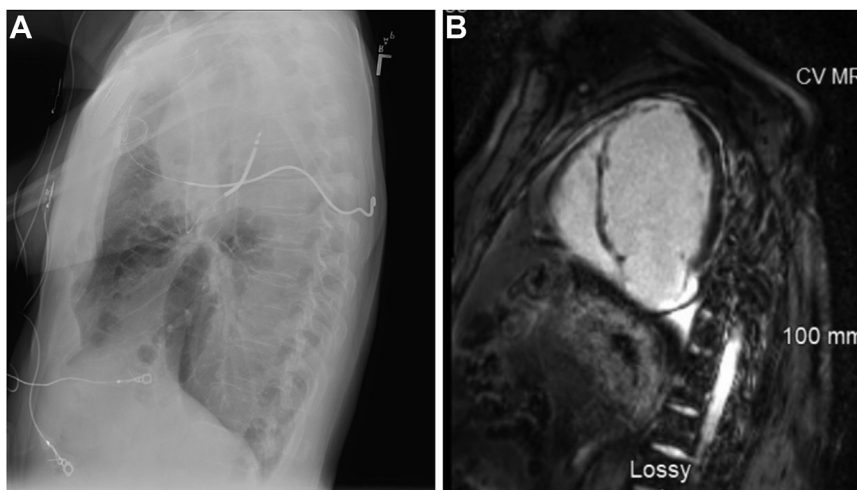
A: Lateral radiograph of implanted implantable cardioverter-defibrillator (ICD) in pneumonectomy patient. B: Prior lateral magnetic resonance imaging is consistent with right ventricular ICD lead placement at the apex.
